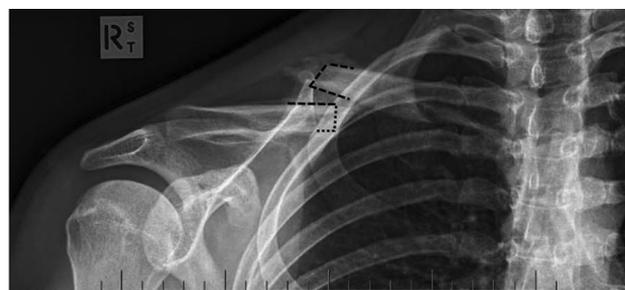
Preoperative radiograph in example case 4. *Dashed lines* indicate osteotomy cut.
